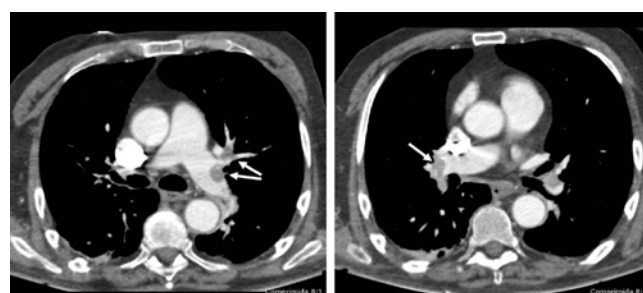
Capture image of a computed tomographic pulmonary angiography showing the bilateral pulmonary embolism (pointed with arrows).
